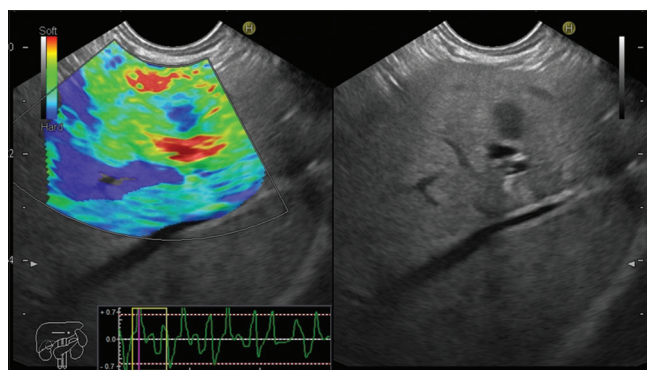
Metastasis in the left lobe of the liver, hard-blue appearance in real-time-endoscopic ultrasound
